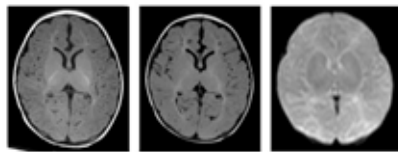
Week 6. From left to right: cerebral MRI in T1, FLAIR, and diffusion-weighted image. This MRI shows the regression of the diffusion-restricted lesions, followed by the appearance of white matter lesions in the frontal cortex with the appearance of cavitation, predominantly on the left side.
